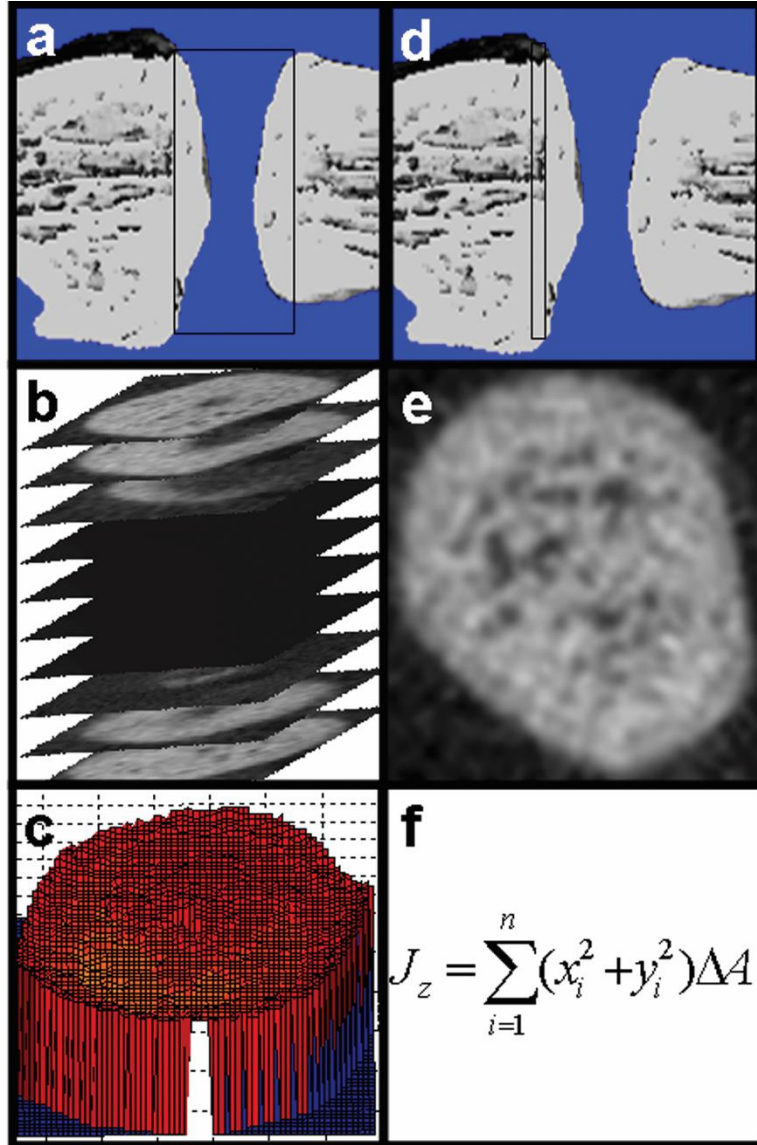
1 μ CT analysis of disc geometry Disc area and mean disc height were measured by (a) isolating the intervertebral space and (b) converting to cross-sectional image stacks. (c) Stacks were analyzed in Matlab by differentiating between pixels that corresponded to bone and pixels that corresponded to disc [32]. Polar moment of inertia, J_z , was measured by (d) isolating a cross-sectional image directly adjacent to the disc space, determining the centroid, and (f) numerically integrating over n pixels (where n is equal to the number of pixels within the boundary of the vertebral body cross-section), each with coordinate (x_i, y_i) and area ($\Delta A = 21\mu\text{m} \times 21\mu\text{m}$, based on μ CT resolution).
